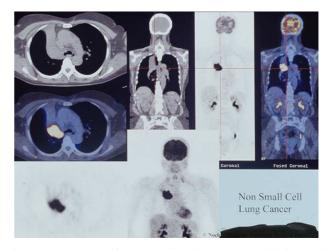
PET scanner of a non-small cell lung cancer (axial views, left images; coronal views, middle and right images) the FDG uptake (appearing in yellow) corresponds to the tumor itself, with a good discrimination between the tumour itself and the obstructive consequence, with an increase in specificity by this combined technic (courtesy of G.K. von Schulthess [59]).
